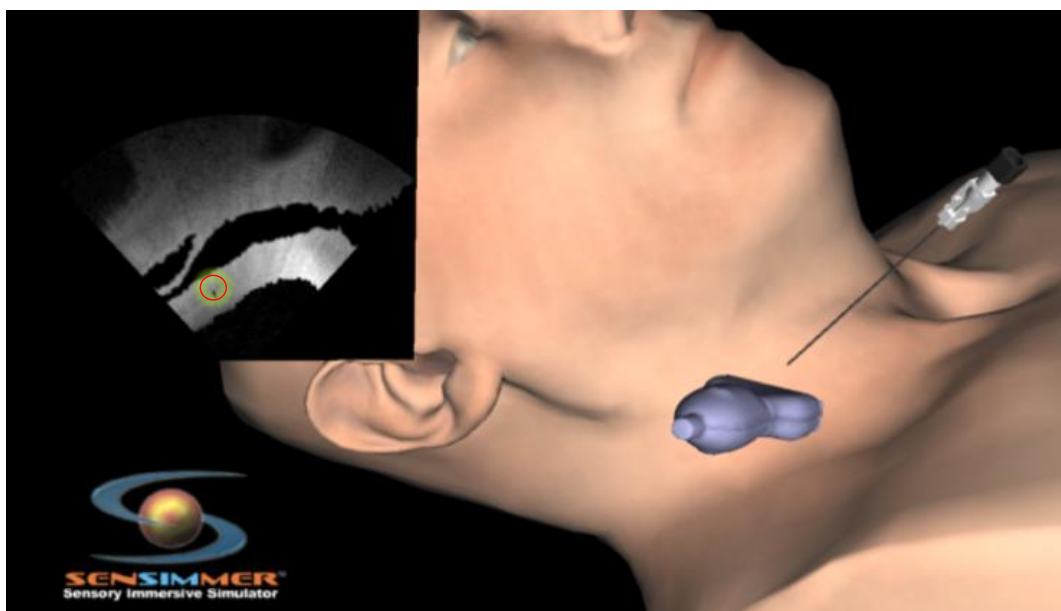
Locating the vein using ultrasound.
